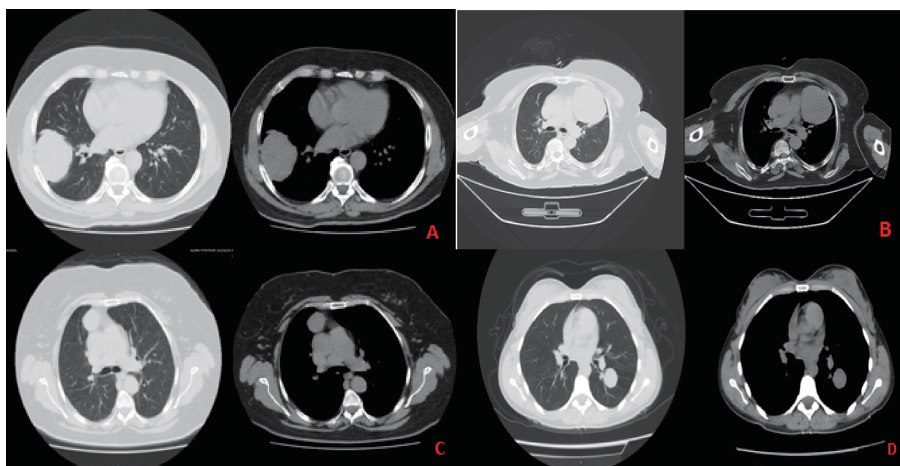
Thoracic computed tomography (CT) findings of pleural solitary fibrous tumors. Axial CT images are shown in both lung window (left) and mediastinal window (right) settings.
